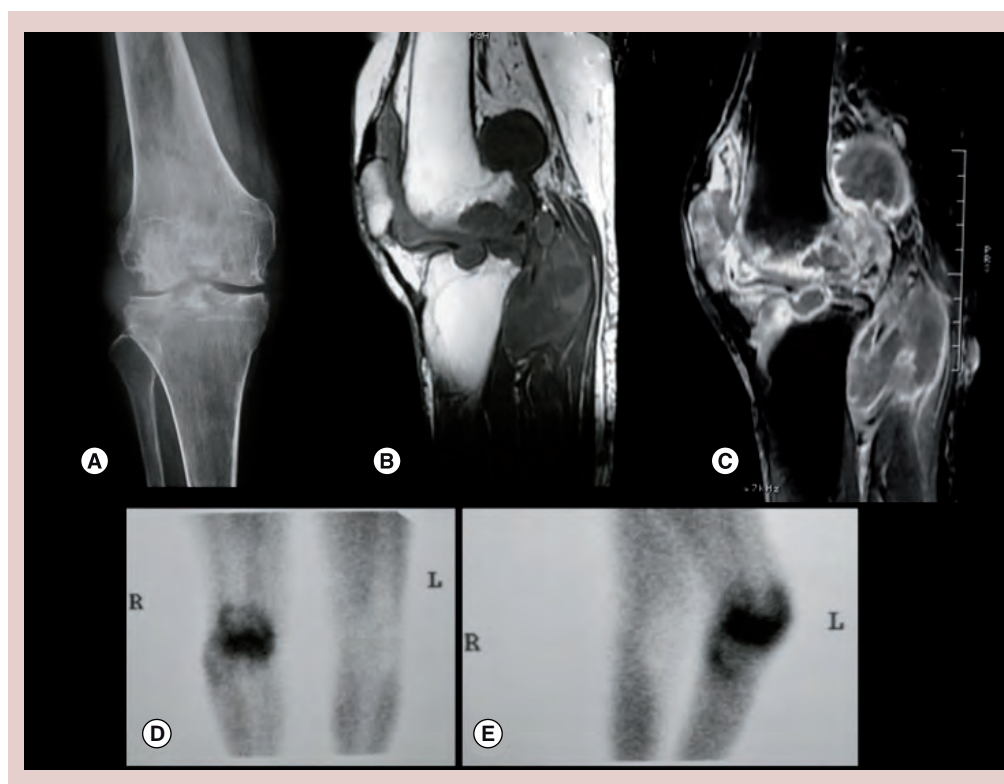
Tuberculous arthritis. (A) Conventional radiography frontal view of the right knee displaying diffuse soft tissue swelling, osteopenia, lateral joint space narrowing and medial and lateral compartment 'corner defects'. (B) Sagittal T2-weighted MRI demonstrates hypointense thickened synovium covering the posterior aspect of lateral condyle affecting the articular joint space, tibial plateau and suprapatellar bursae. (C) Sagittal T2 fat-saturation MRI with enhancement of the liquid collection and cortical defects. (D & E) Anterior and lateral view of a methoxyisobutylisonitrile-technetium-99m showing diffuse captation in the right knee.
